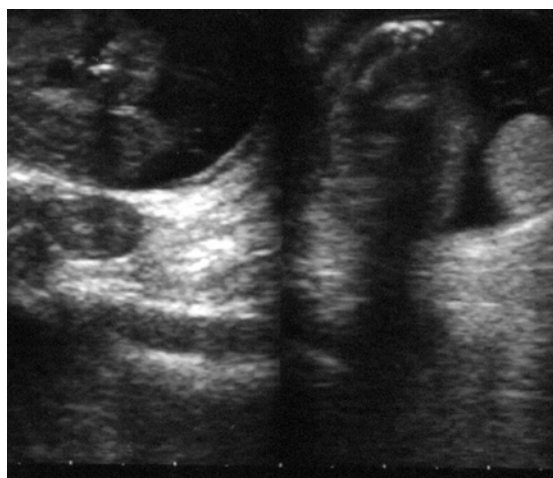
Gray-scale ultrasound showing intestinal loops in the right inguinal canal and adjacent testis with normal size and echogenicity.
